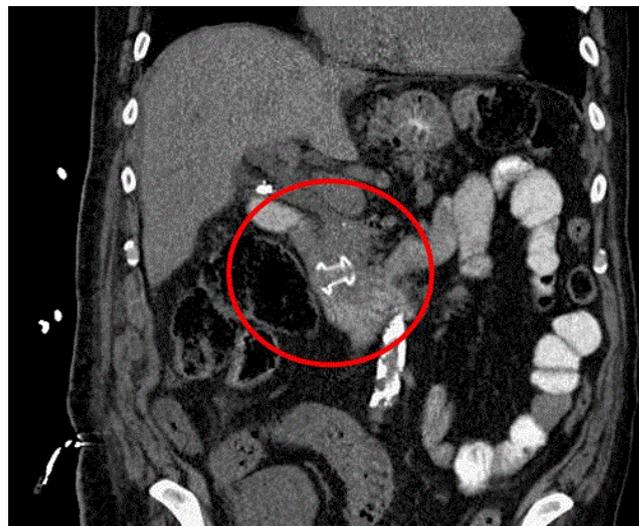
Patient's symptoms resolved and repeat CT four weeks later revealed marked decrease in the PFC size.
